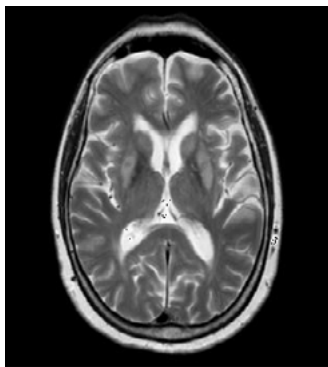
MRI brain with demyelination features.
